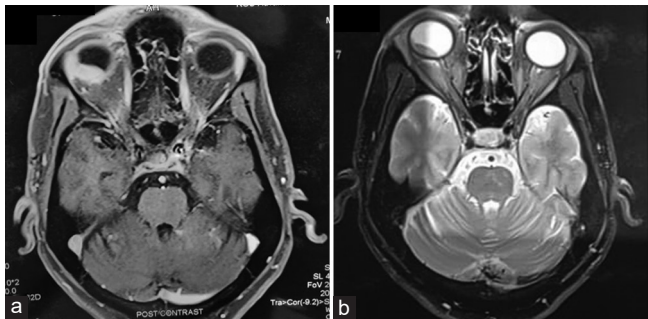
Magnetic resonance imaging at presentation showing a 16 mm × 8 mm choroidal mass which was (a) hyperintense on T1-weighted images and (b) hypointense on T2-weighted images
